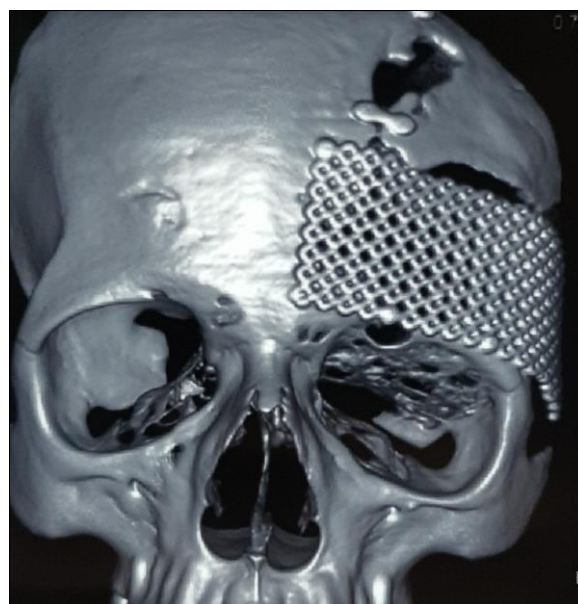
Preoperative 3D CT scan of the patient, there is a gross difference in orbital volumes, the left orbit is shallower with low orbital roof. Vertical orbital dystopia can be appreciated. Also note the titanium mesh in place from the previous surgery.
